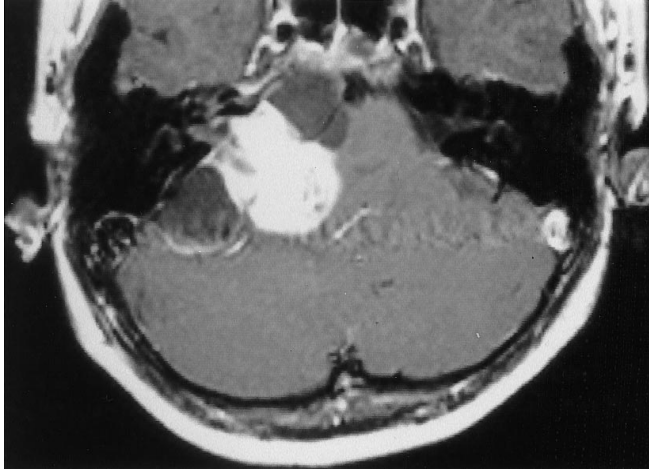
Contrast-enhanced T1-weighted axial image shows a cerebellopontine angle mass extending into the widened internal auditory meatus
